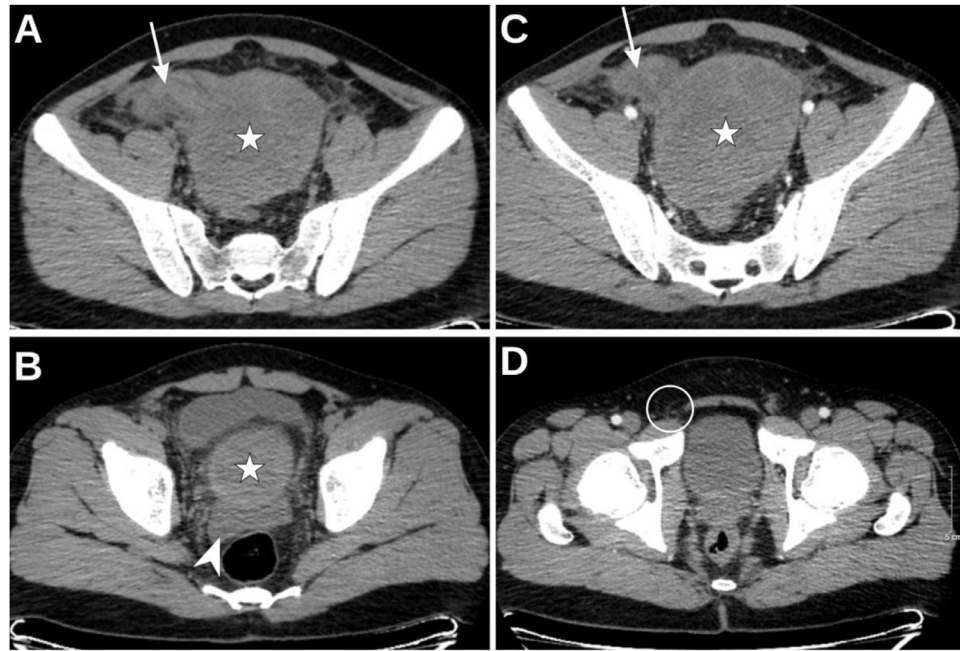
Axial CT images of the abdomen and pelvis. (A–B) Noncontrast CT shows a well-defined soft-tissue mass (star) in the hypogastric region (~60 × 62 × 92 mm) with surrounding fat stranding and a twisted pedicle (white arrow). Small pelvic free fluid is also noted (white arrowhead). (C–D) Arterial phase images demonstrate minimal enhancement of the mass (star). The pedicle appears edematous (white arrow). Absence of the right spermatic cord in the inguinal canal (circle) raises suspicion for intra-abdominal testicular torsion.
